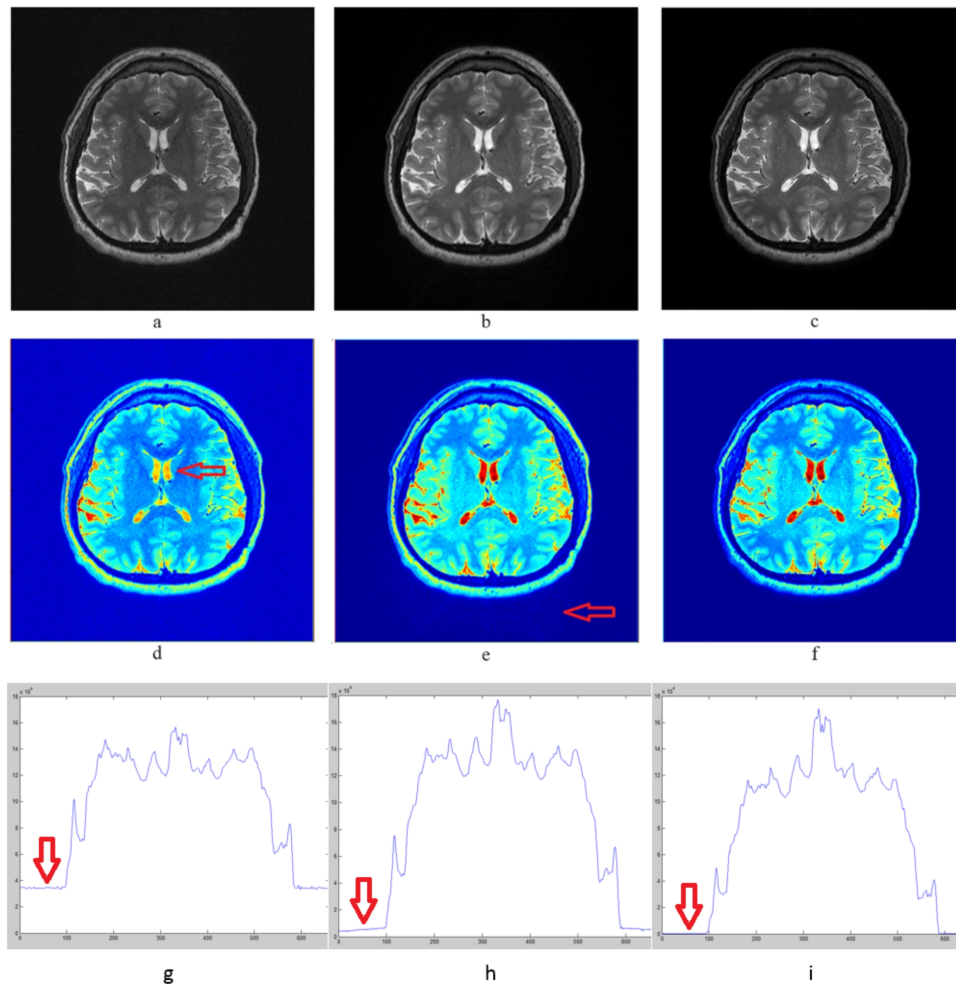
Out puts of a scan without acceleration. Each channels signal data is combined with different methods. (a) SoS of absolute signal data from 32 channel; (b) MRI machines output image; (c) Our methods combination. Second row images: (d), (e) and (f) are the jet colored images of the gray scale (a), (b) and (c) respectively. In this set red arrows show the signal values outside the object regions. Third row images: (g), (h) and (i) are the pixel value sums in vertical direction of images in (a), (b) and (c) respectively.
